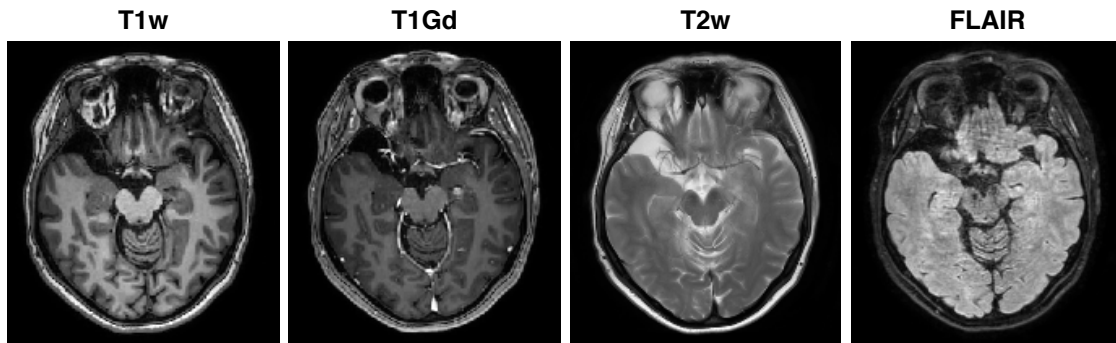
A slice of a brain scan acquired with four different MRI modalities. The T1w scan shows a good contrast between white and gray matter, while the T1Gd scan enhances the vasculature. The T2w scan enhances fluid, while a signal from free water is suppressed in the FLAIR scan.
